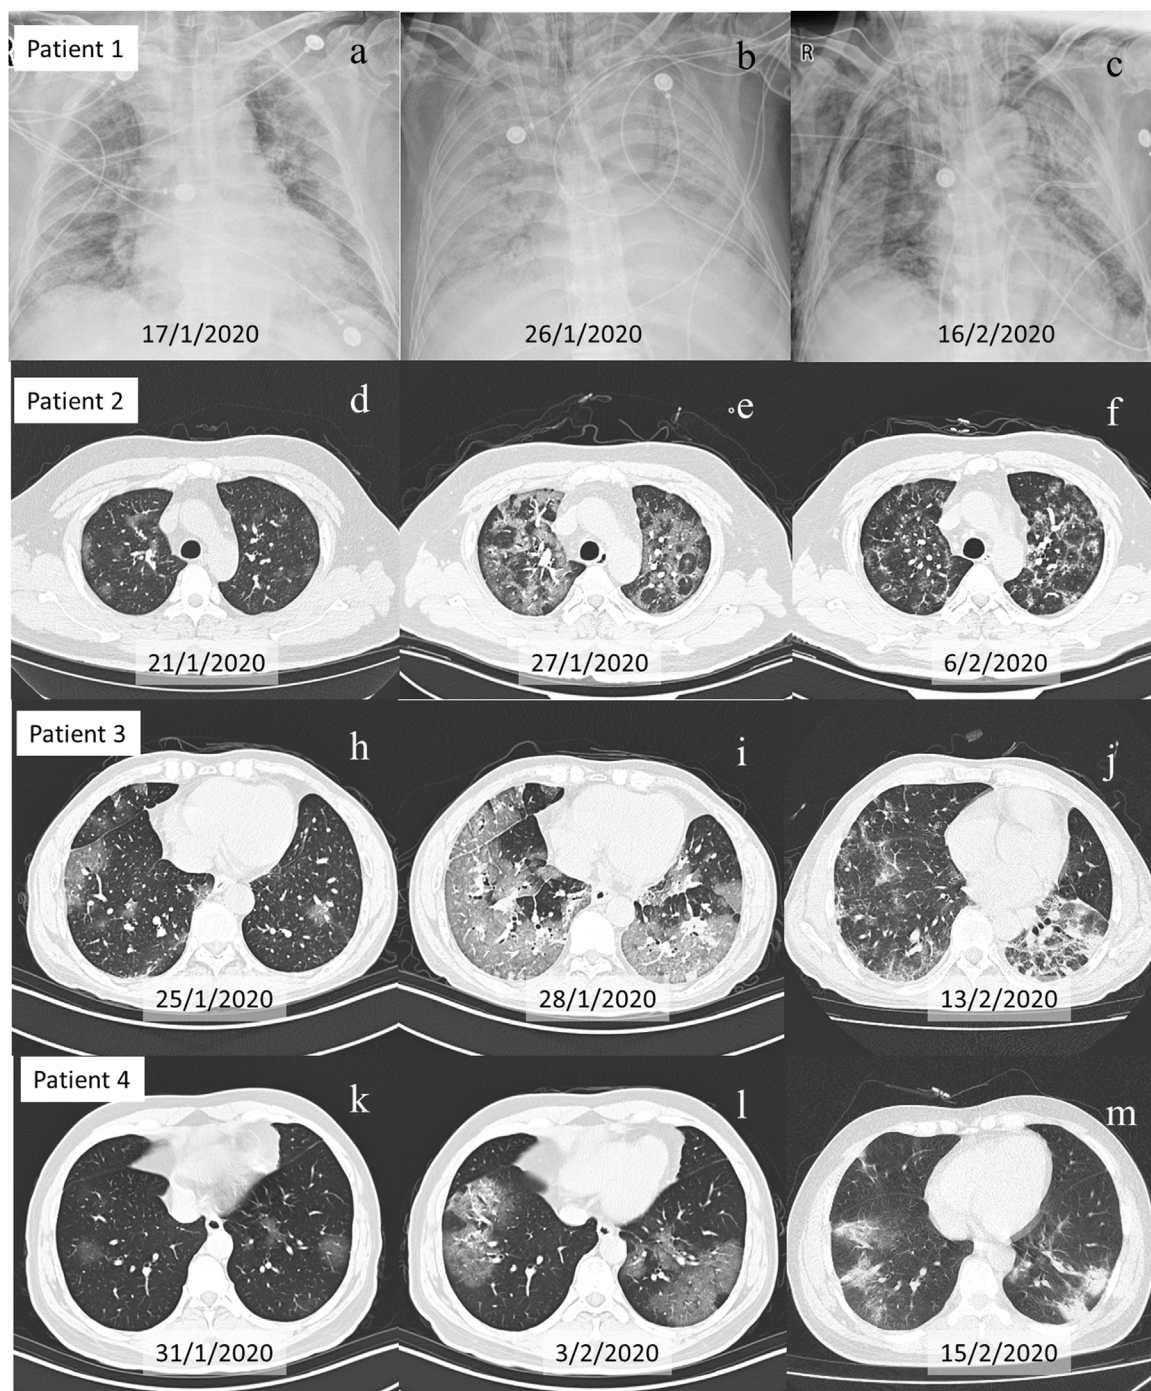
Evolution of chest X-ray and CT scans of four patients with viremia. Figure (a–c), Figure (d–f), Figure (h–j), and Figure (l–n) show chest X-ray and CT scans of patient 1, 2, 3 and 4, respectively. Figure (a), Figure (d), Figure (h), and Figure (k) show mild lesions on admission. Figure (b), Figure (e), Figure (i) and Figure (l) show excessive new ground-glass exudate on CT scans the same or next day positive SARS-CoV-2 nucleic acid test in blood was first detected. Figure (c), Figure (f), Figure (j) and Figure (m) demonstrated recovery of pneumonia after SARS-CoV-2 nucleic acid becoming negative in blood. For patient 1, even after pneumonia was somewhat improved in Figure (c), other organs dysfunction persistently was observed due to extended viremia.
